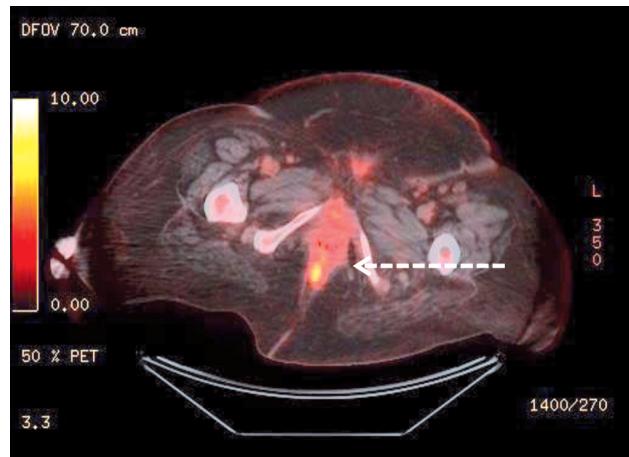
Axial PET/CT image 18 months after surgery.
